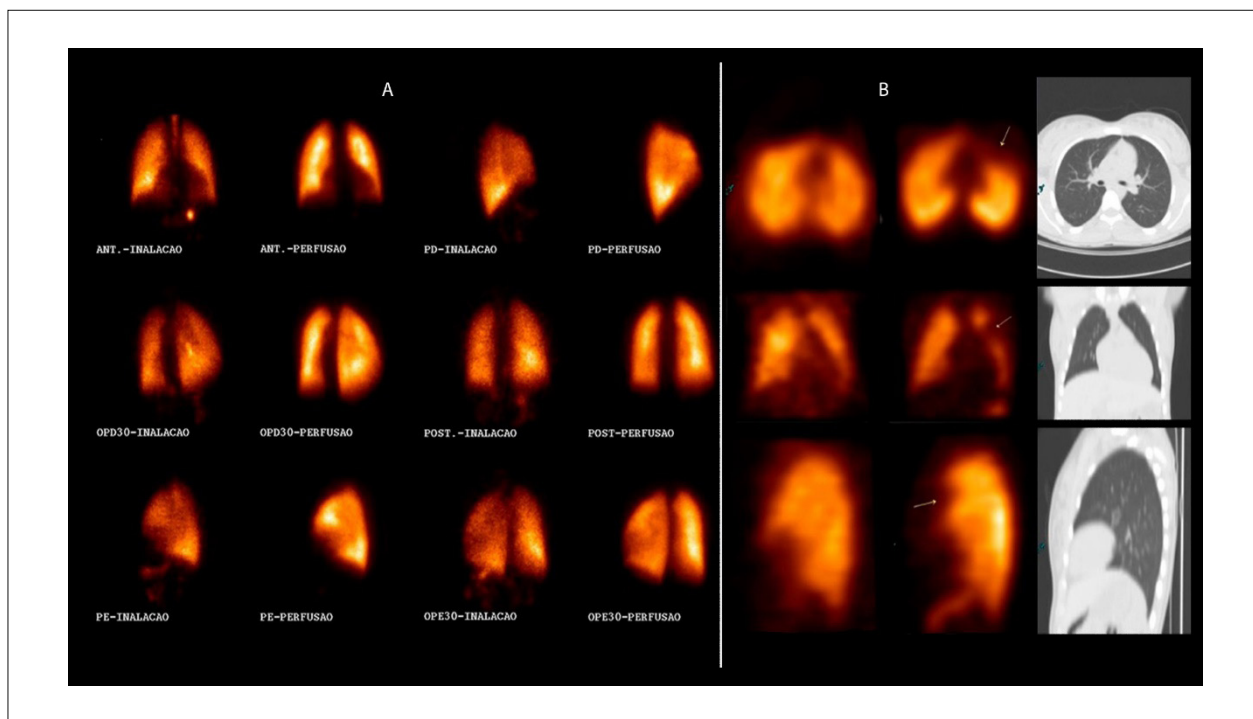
A: series of images of planar V/Q scintigraphy with ^{99m}Tc -labeled DTPA/MAA, with the anterior, posterior, lateral, and oblique views showing normal ventilation and perfusion. B: series of images of V/Q SPECT combined with low-dose CT with ^{99m}Tc -labeled DTPA/MAA, from left to right: first column, ventilation SPECT; second column, perfusion SPECT; and third column, chest CT. The ventilation image is normal, while the perfusion image shows a perfusion defect in the lower segment of the left upper lobe (arrow) and normal CT, which characterizes PE.
